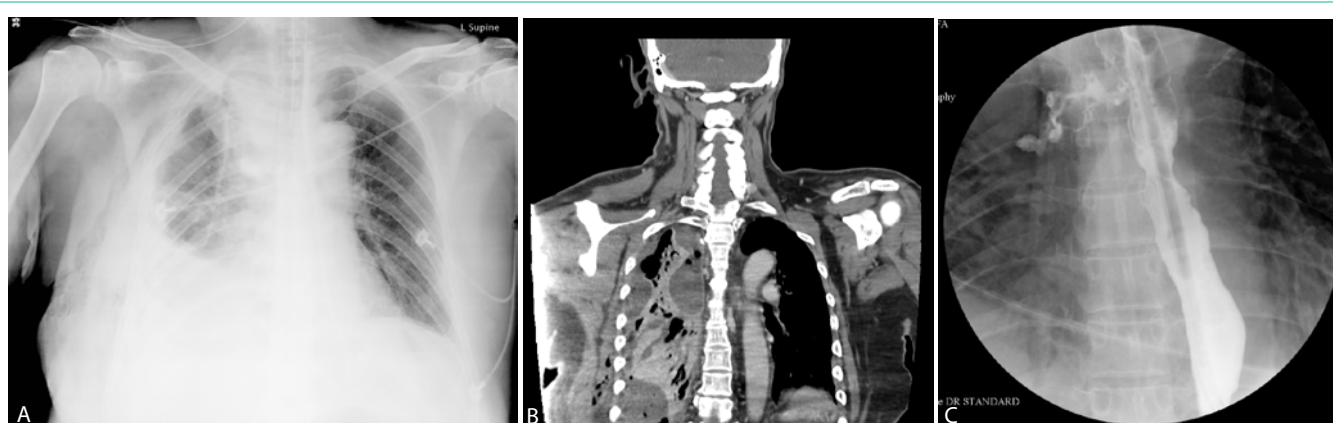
(A) X-ray shows right loculated pleural effusion. (B) Computed tomography shows right loculated pleural effusion containing gas with right lower lobe lung consolidation. (C) Esophagography demonstrated contrast media extravasation from upper-third esophagus.
